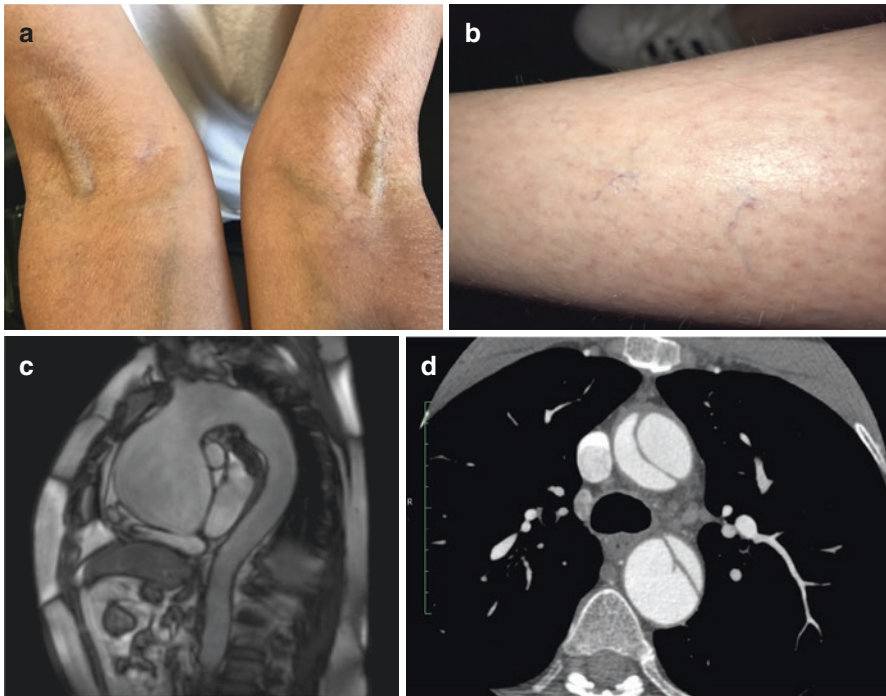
Clinical features of non-syndromal thoracic aortic aneurysm. Panel A: Enlarged cubital fossa veins and valgus deformity. Panel B: Spider veins on lower leg in early life. Panel C: MR aortogram showing giant aneurysm of ascending aorta. Panel D: CT aortogram showing aortic arch dissection and dilatation of ascending and descending aorta
